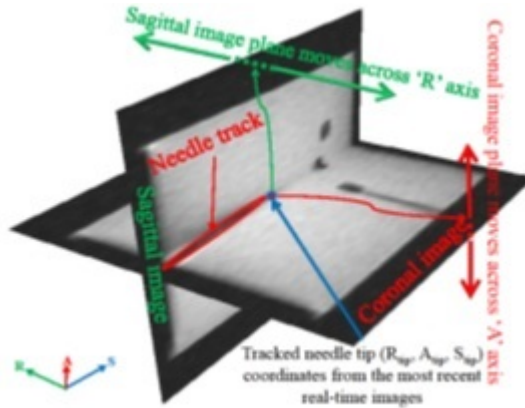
Needle localization using multi-planar MR images. The 3D coordinates of the needle tip are found by localizing the tip in two perpendicular images [94].
